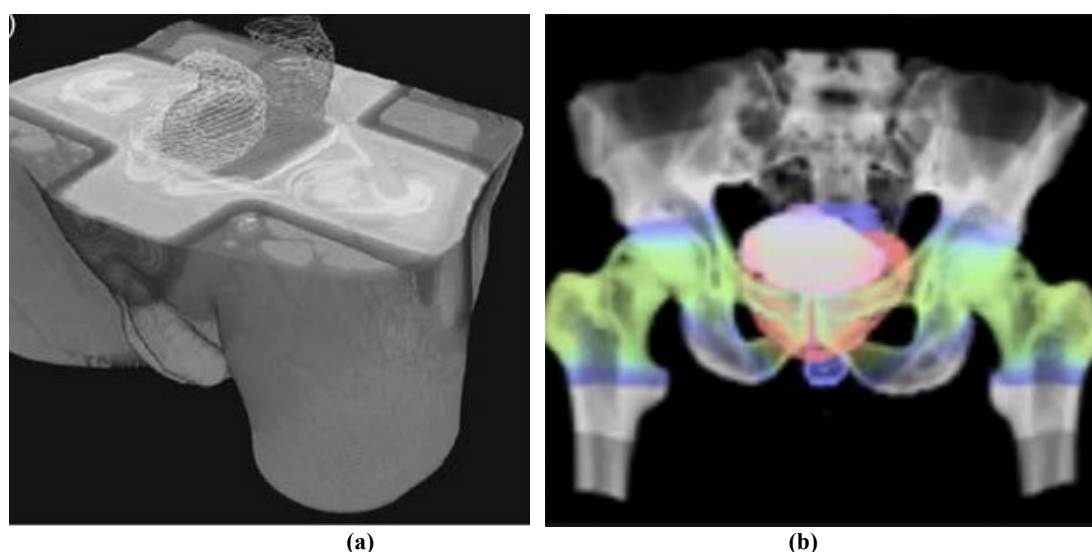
(a) Visualisation of the dose distribution on the surface of a selected CT data volume is achieved by making all but the lowest values of the transfer function opaque. (b) Visualisation of the dose distribution on the bony structures is achieved by making areas of high CT values opaque and areas of low CT values transparent (from (Patel et al., 2007)).
